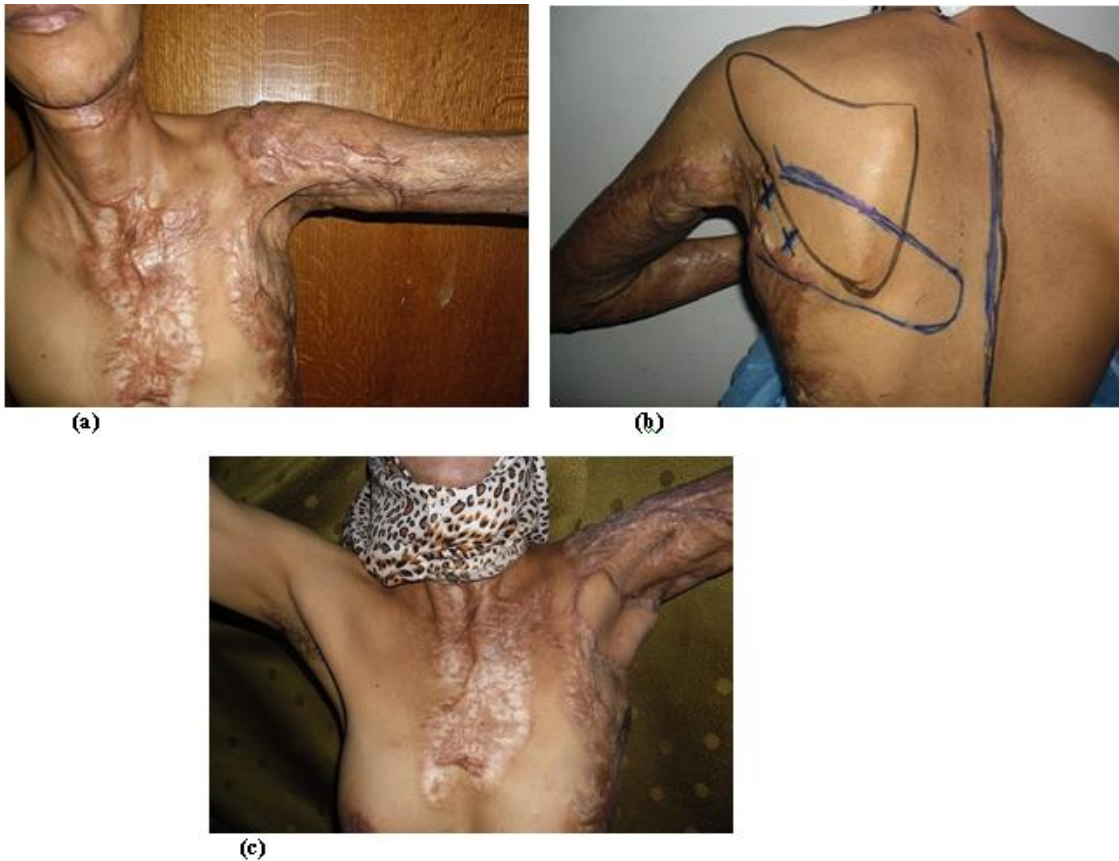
(a), female patient with type (III) post. Burn lt sided axillary contracture. (b), the same patient; after preoperative marking of the propellar CSAP and the flap with a handheld Doppler. (c), the same patient four months after discharge with complete healing of the flap and improved degree of shoulder abduction.
